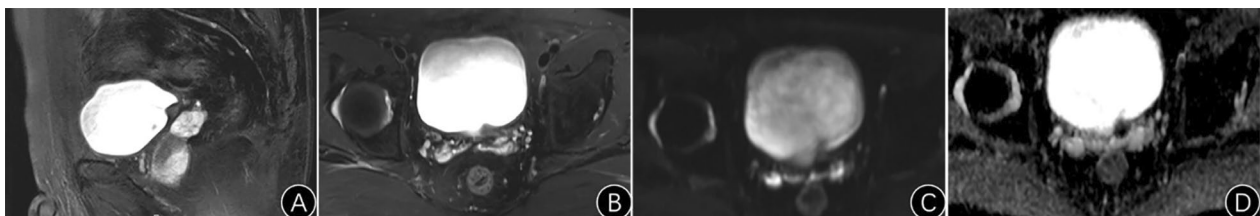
A, T2-weighted imaging demonstrating complete separation of the mass at the end of the ureter from the prostate; B, T2-weighted imaging revealing a slightly low signal from the lesion; C, diffusion weighted imaging showing a slightly high signal from the lesion; D, apparent diffusion coefficient indicating a low signal from the lesion
